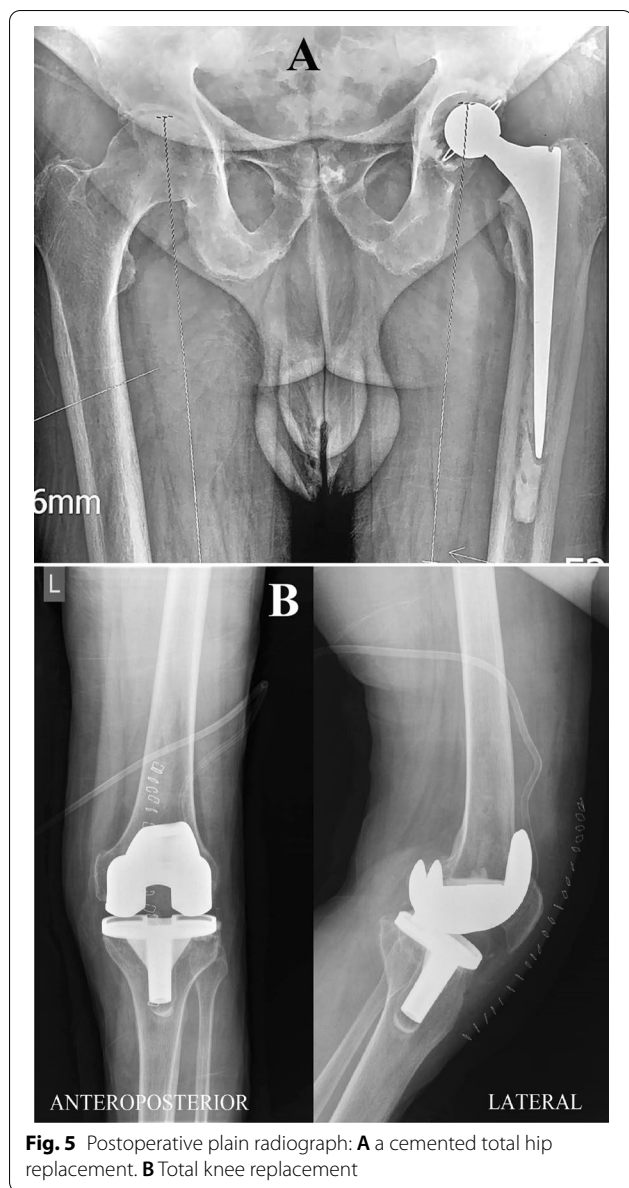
Postoperative plain radiograph: A a cemented total hip replacement. B Total knee replacement
